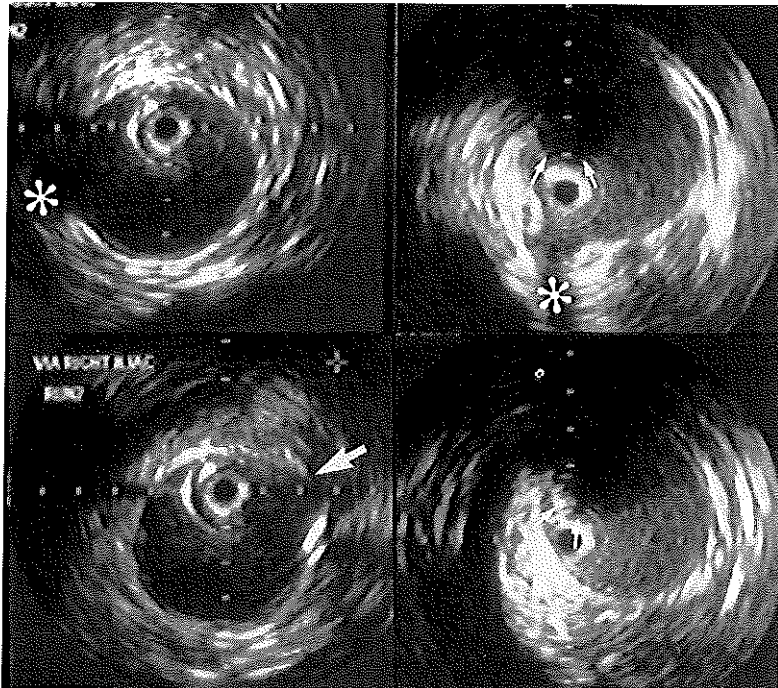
Intravascular ultrasound images (10 MHz) showing the right renal artery and vein obtained immediately before placement of an endovascular graft. In the presence of the delivery system of an Ancure endovascular graft (EndoVascular Technologies/Guidant, Menlo Park, CA, USA), shadowing of 25% of the vessel wall occurs preventing visualization of the left renal artery.
